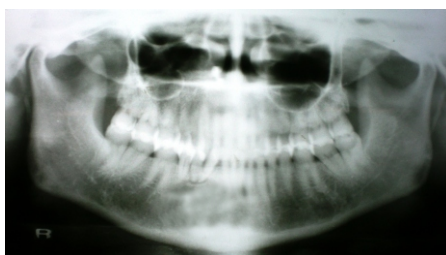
Postoperative panoramic radiograph after six months
